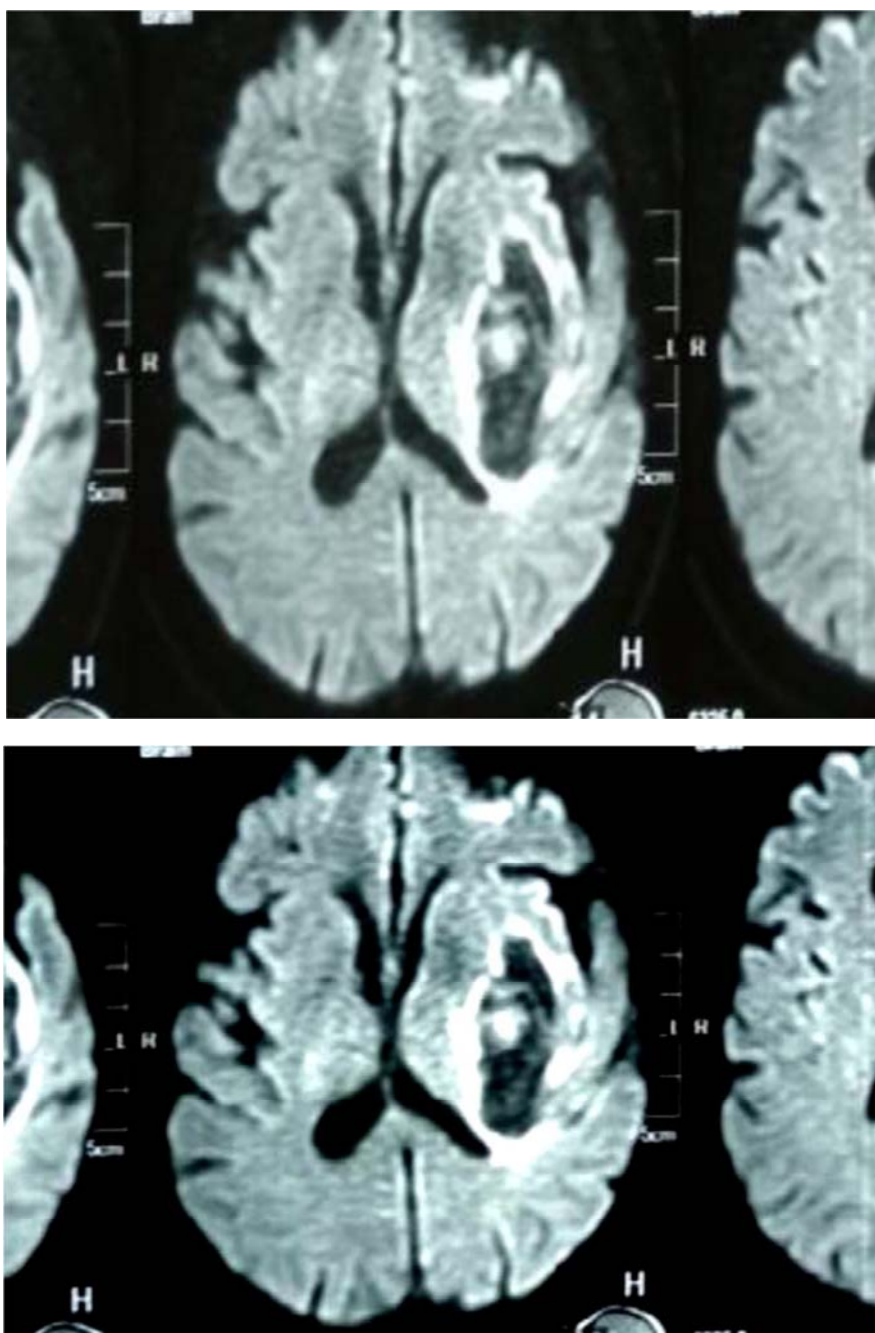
MRI-type brain scan - intracerebral stroke hematoma.
